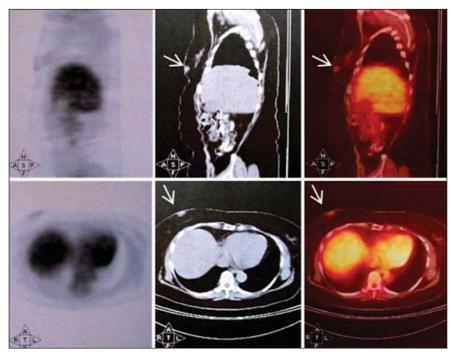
Positron emission tomography/computed tomography (FDG-PET/TC) demonstrating increases FDG uptake in a breast (arrows).
